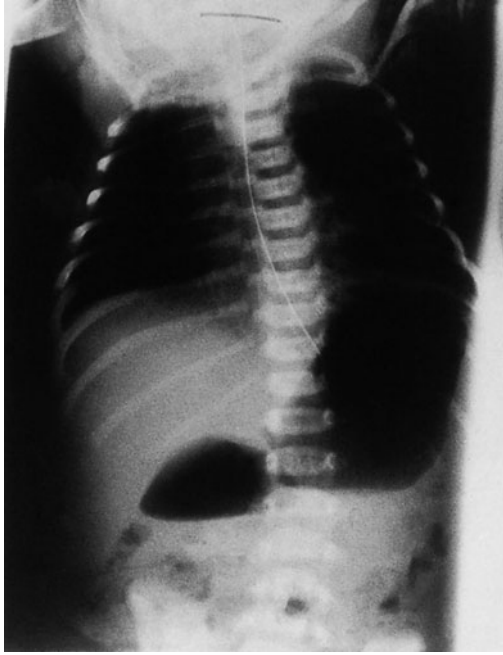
Duodenal stenosis erect abdominal x-ray demonstrating a double bubble sign with air beyond the duodenum.
